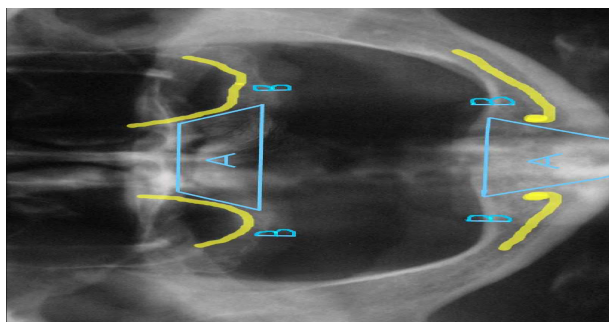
Assessing the relationship with the nearby anatomical structures by orthopantomography analysis.
